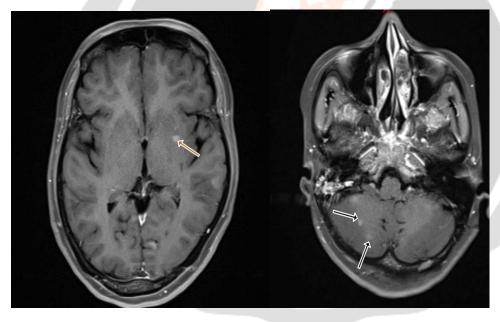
Figure A and B-MRI-Brain showing mets
